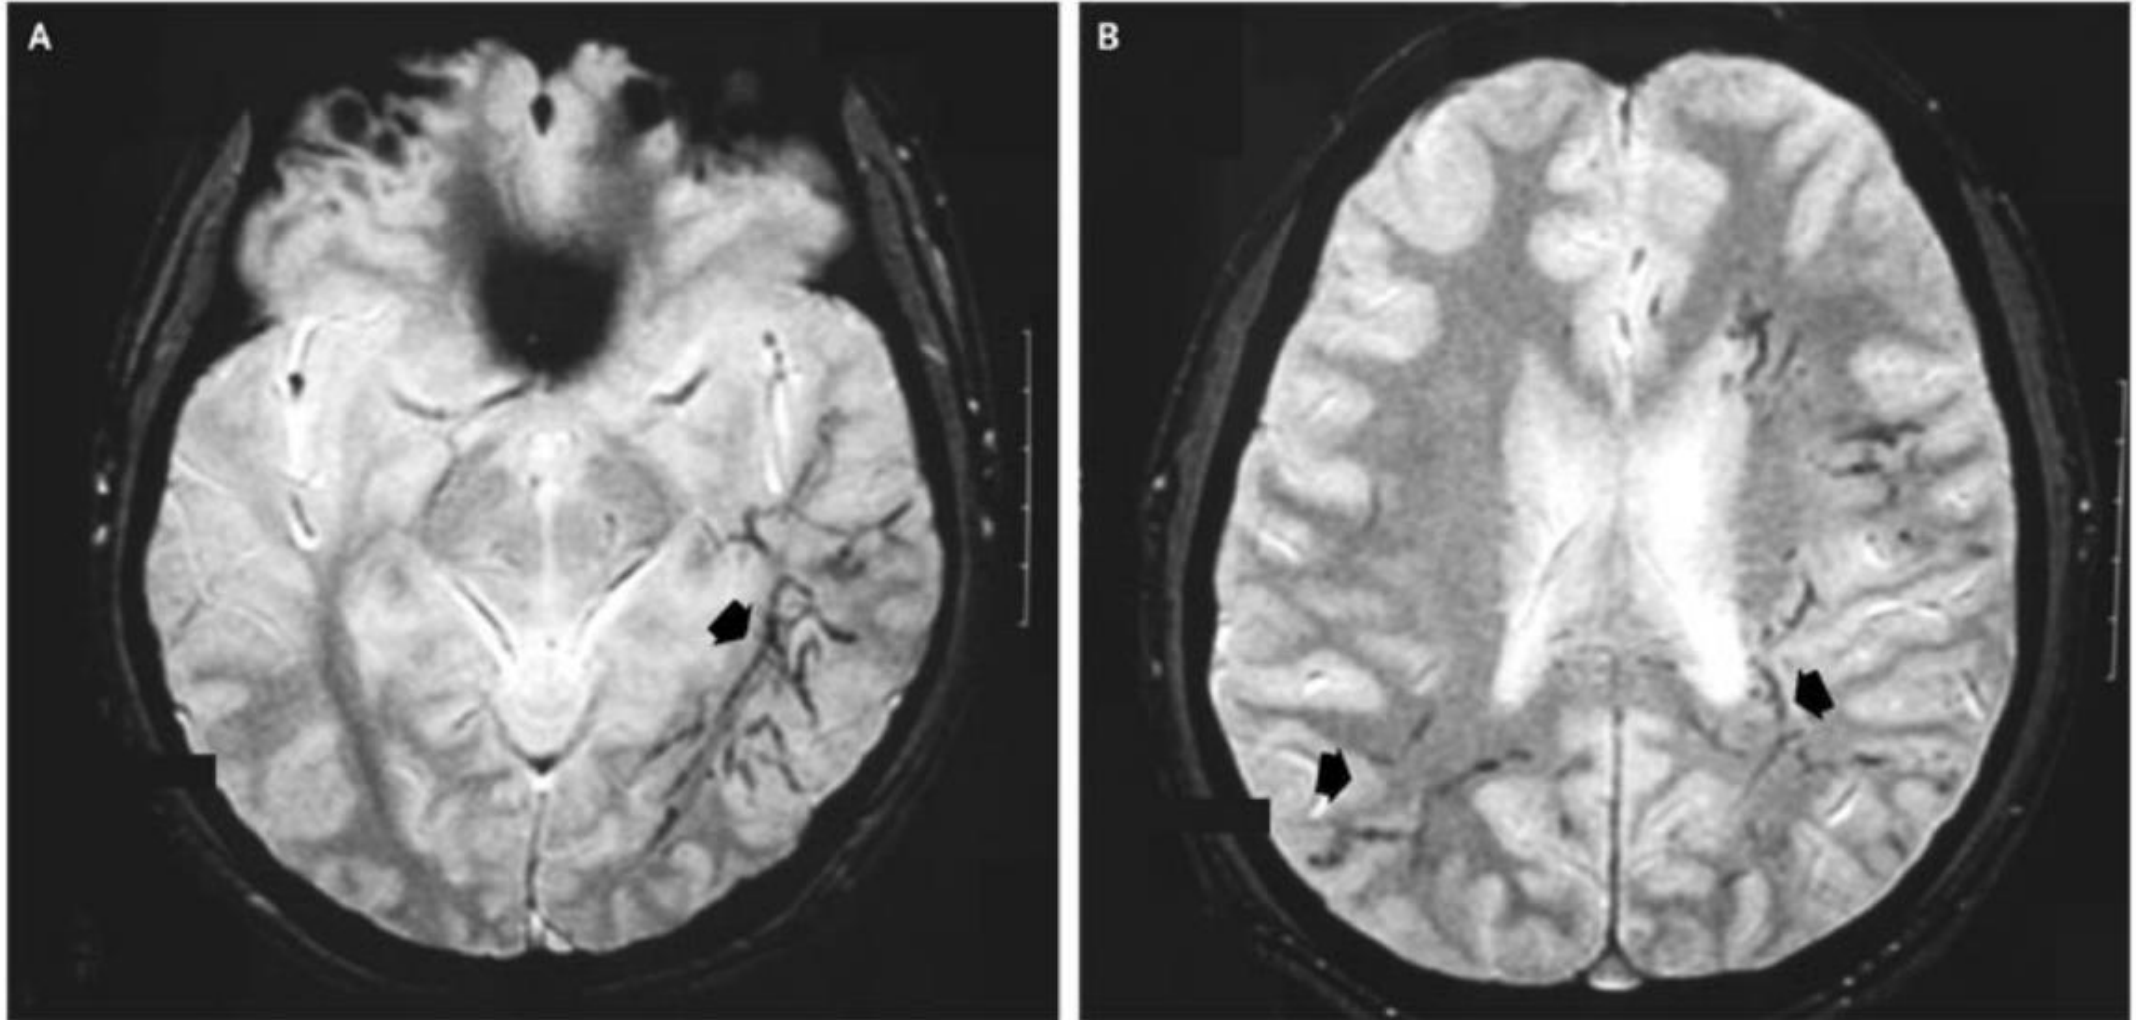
MRI of the brain showed hemorrhagic tract at corpus collasum and subarachnoid hemorrhage at left sylvian fissure caused by *G. spinigerum*.
